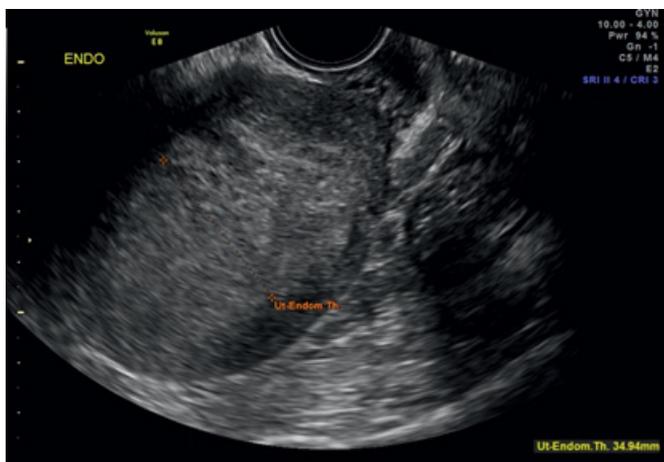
Ultrasound image of the uterus with findings concerning for EIN or endometrial cancer.
